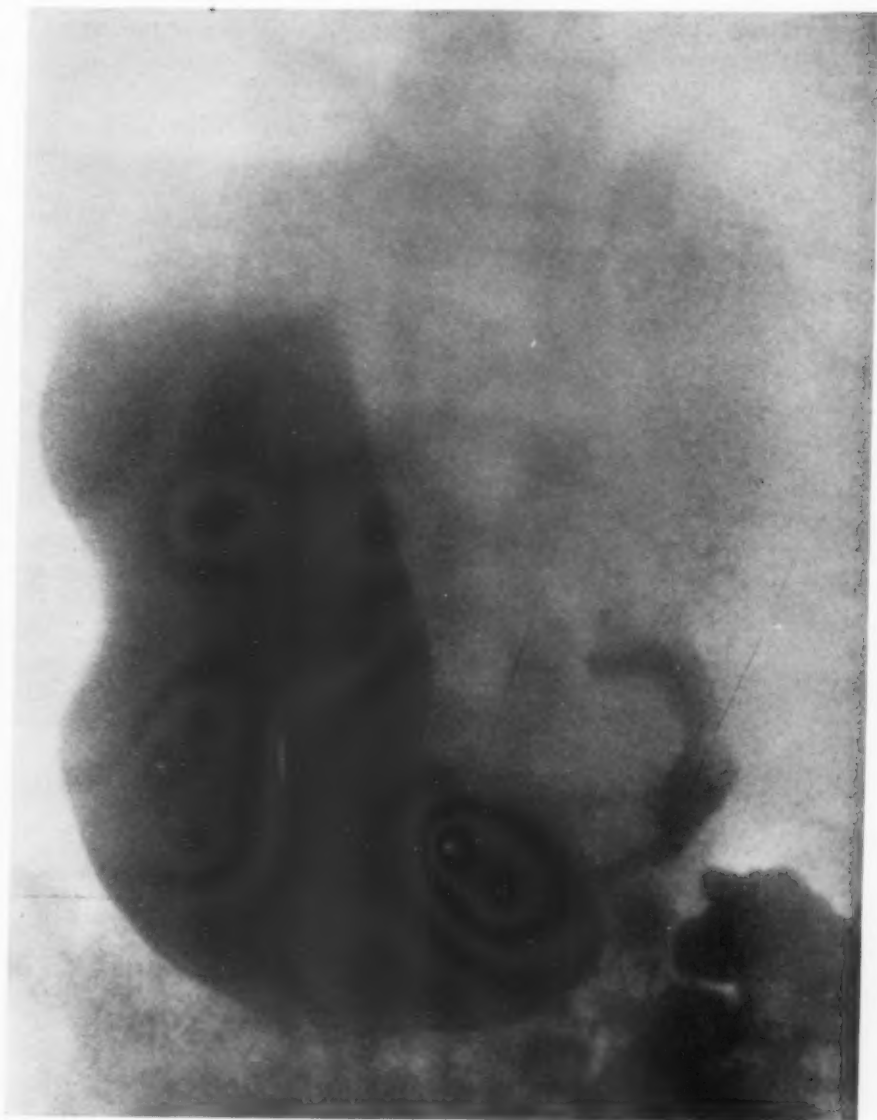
X-ray of carcinoma shown in Fig. 2.
